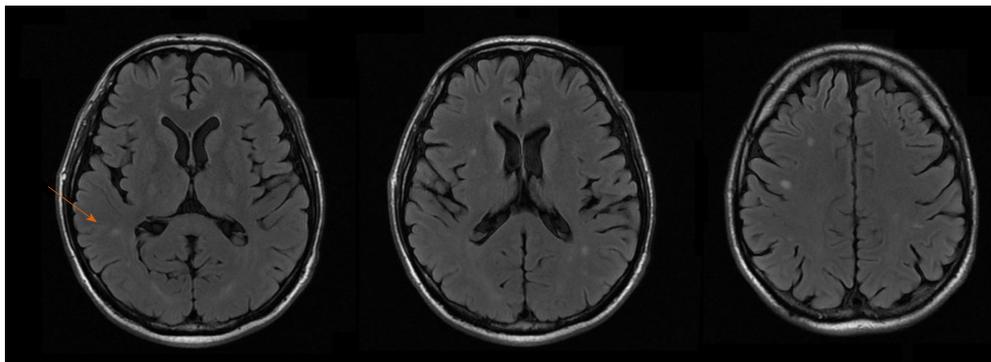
Magnetic resonance imaging of the brain. Multiple diffuse small lesions (arrow) in brain cortex and subcortical regions, with edematous halo and peripheral enhancement, suggestive of fungal infection (cryptococcomas).
